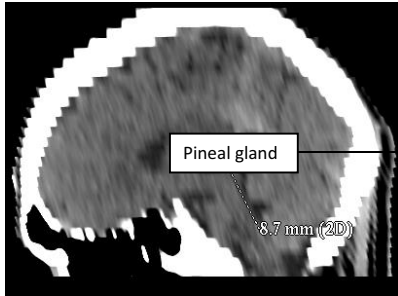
CT scan head (Sagittal section) showing length of pineal gland.
